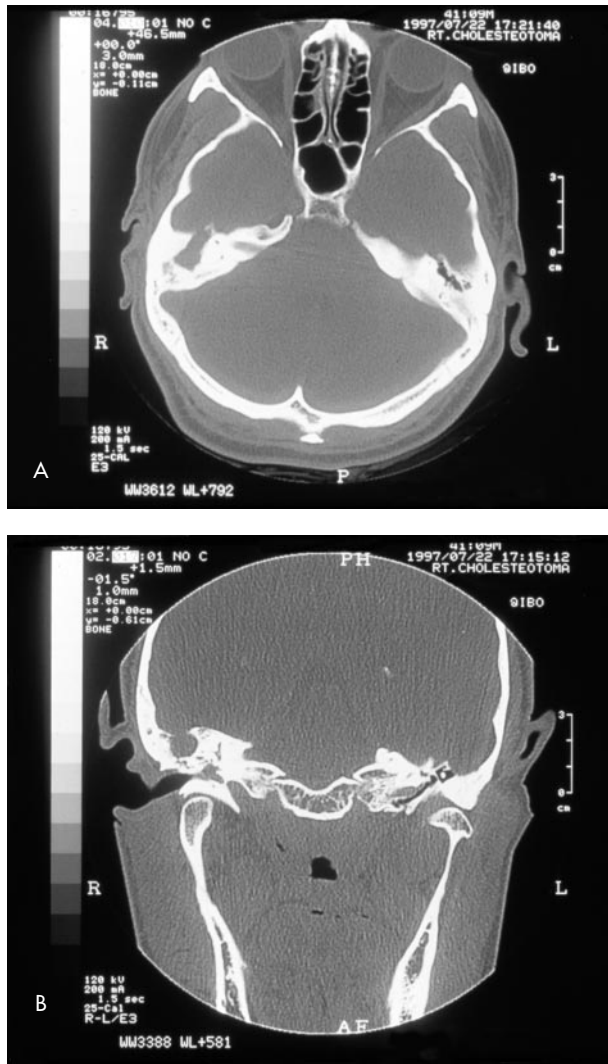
Coronal computed tomographic scan demonstrating attic cholesteatoma engulfing the ossicular chain in the left ear.
